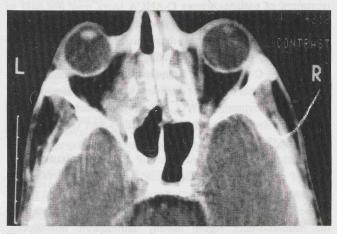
CT scan of the orbit showing an ethmoid mass extending into the retro-orbital area, destroying the medial wall of the orbit.
